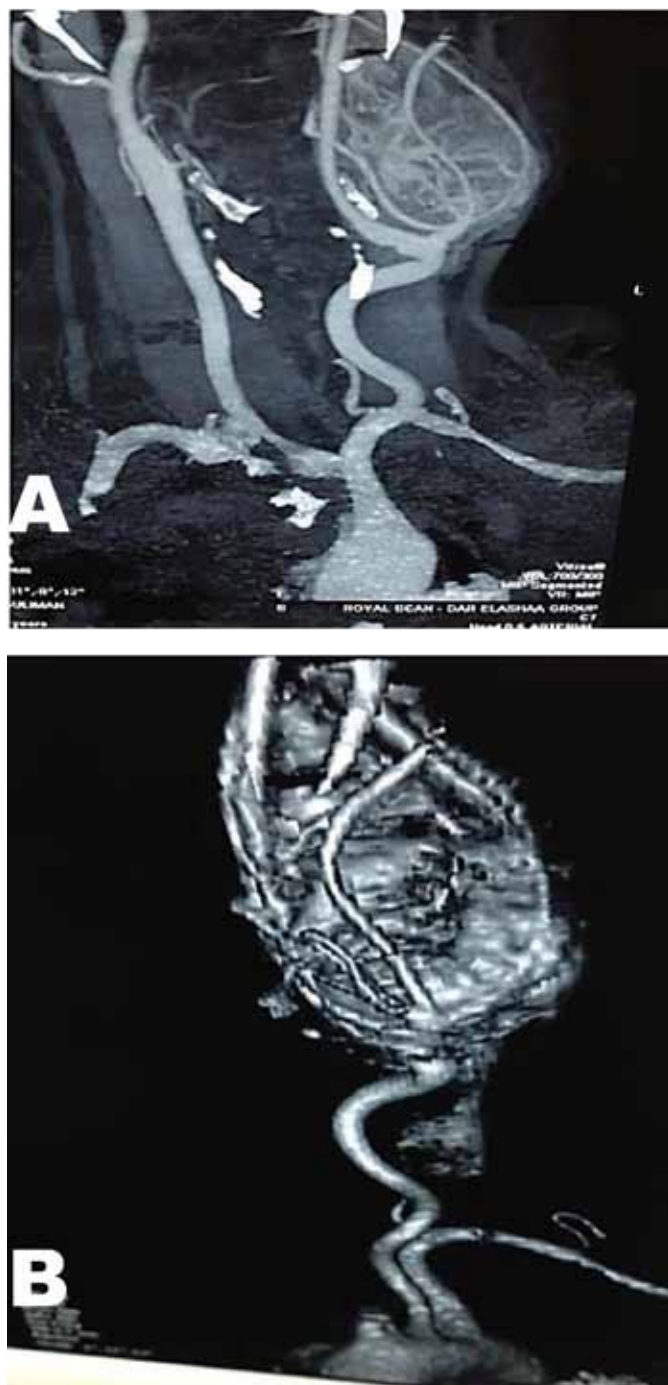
Imaging studies (A) MRA (B) Computed tomography angiography showing a carotid body tumors arising at the bifurcation of common carotid artery, which has rich blood supply, splaying the external carotid artery.
